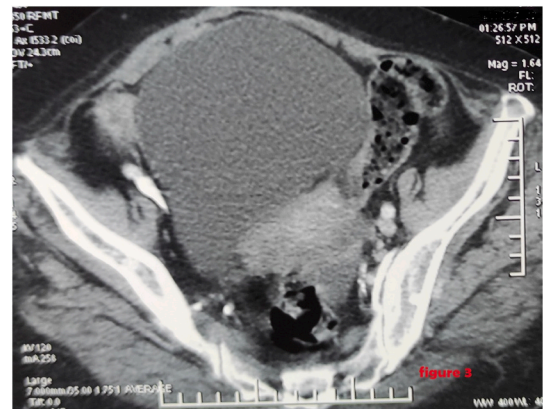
CT scan of control showed a solid-cystic, pelvic mass with lobulated contours, encompassing the uterus.
